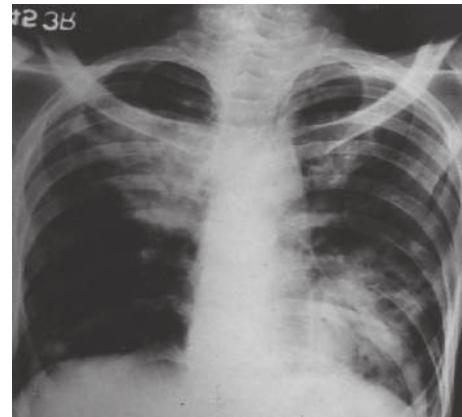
Chest radiograph of a patient with GPA shows parenchymal lesions in the lungs in an asymmetrical pattern; these shadows may keep changing their size, shape and position in patients with GPA over days
